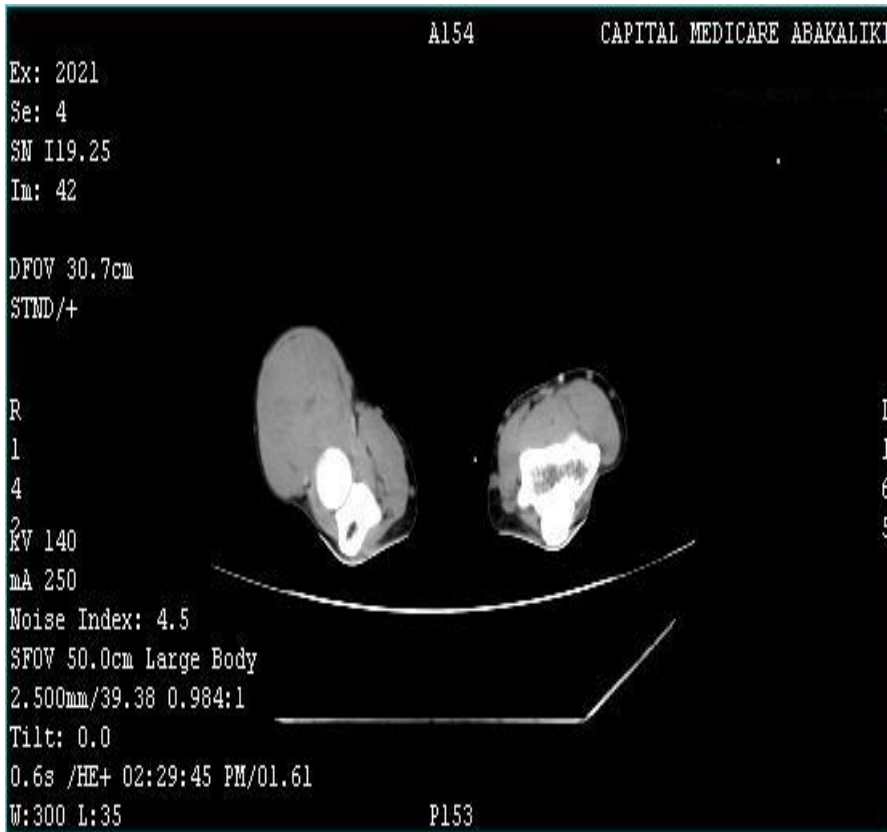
Axial computed tomogram of both elbows showing moderately enhancing soft tissue mass on the left elbow (arrows).
